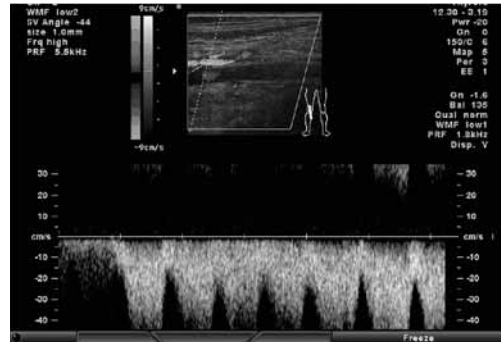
First Doppler ultrasound registered high flow and high systolic peak values in the popliteal, superficial and deep femoral vein (horizontal orientation).
